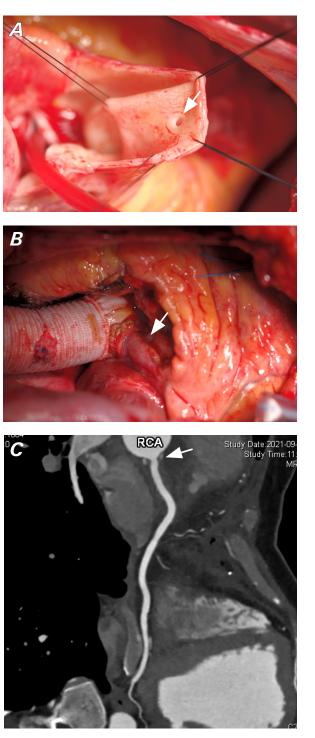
A) Operative findings are a patent right coronary ostium and B) suitable length of the right coronary button (white arrow). C) Postoperative computed tomography coronary angiogram shows minimal stenosis of the RCA.
